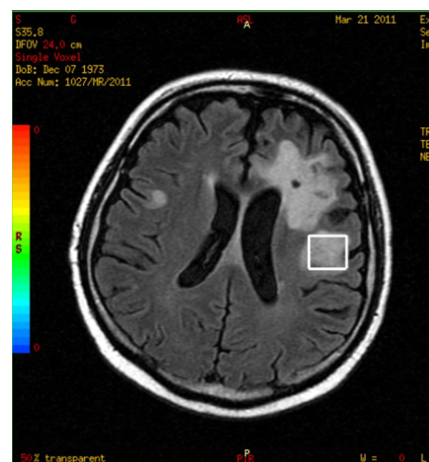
Brain MRI (21 March 2011).
